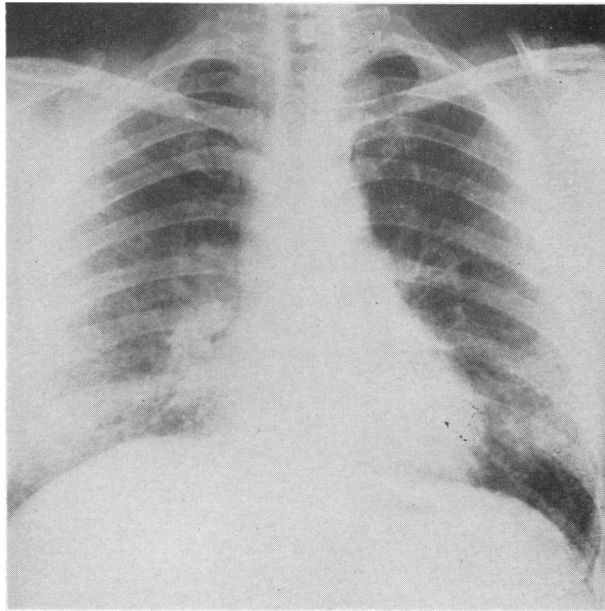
Case 2. Radiograph of chest, August, 1959, before treatment, showing extensive bilateral miliary and fine nodular shadowing.
